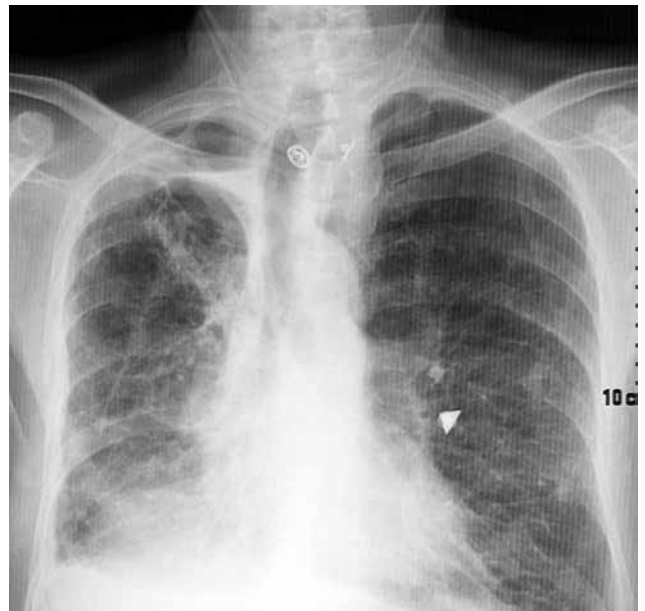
Postoperative chest X-ray showing small apical space and a well expanded right lung.
